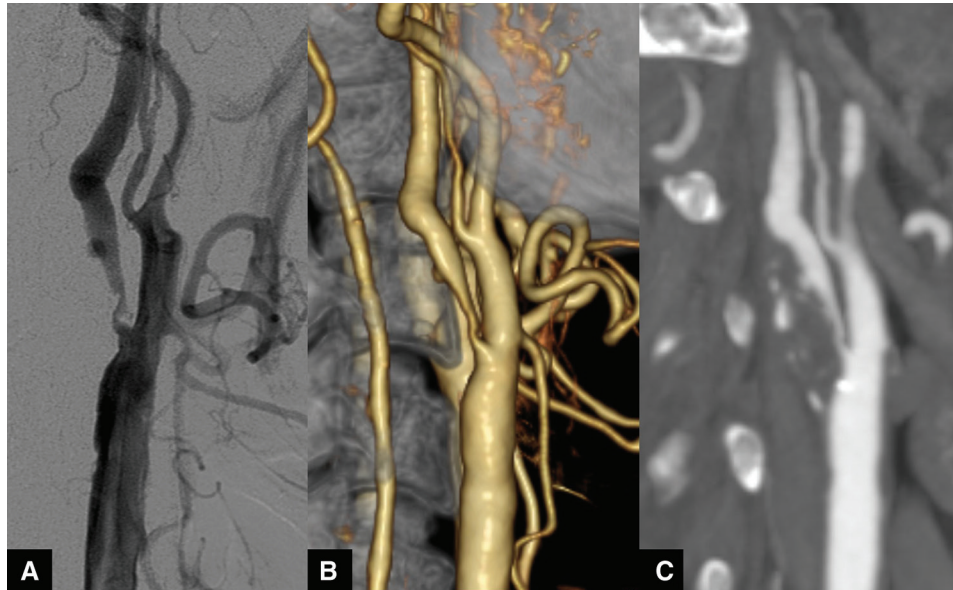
Preoperative DSA (A) and CTA (B, C) reveal stenosis of the ICA and the CCA. Calcification is observed at the site of stenosis (C). CCA: common carotid artery; ICA: internal carotid artery
